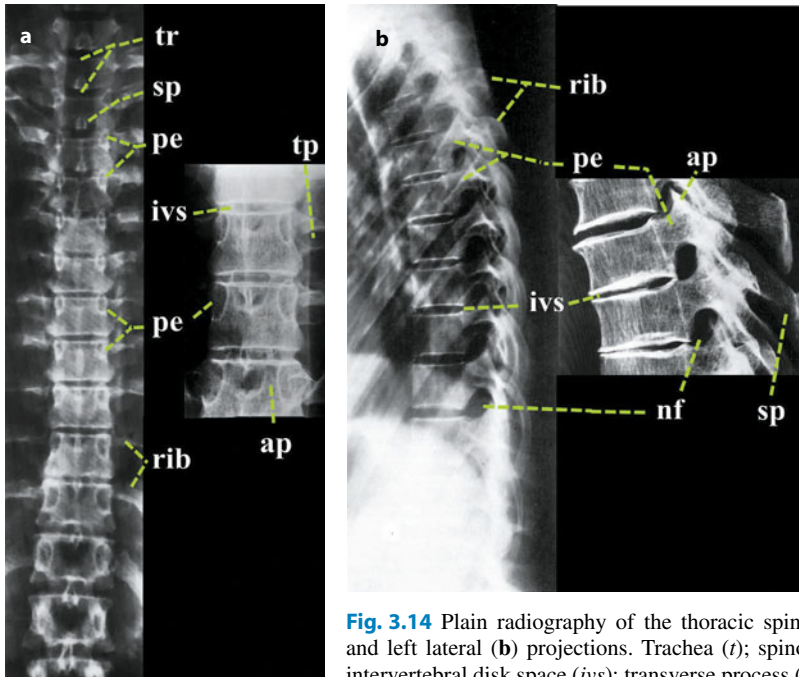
Plain radiography of the thoracic spine showing anteroposterior (a) and left lateral (b) projections. Trachea (*t*); spinous process (*sp*); pedicle (*pe*); intervertebral disk space (*ivs*); transverse process (*tp*); articular process (*ap*); vertebral body (*vb*); neural foramen (*nf*)
